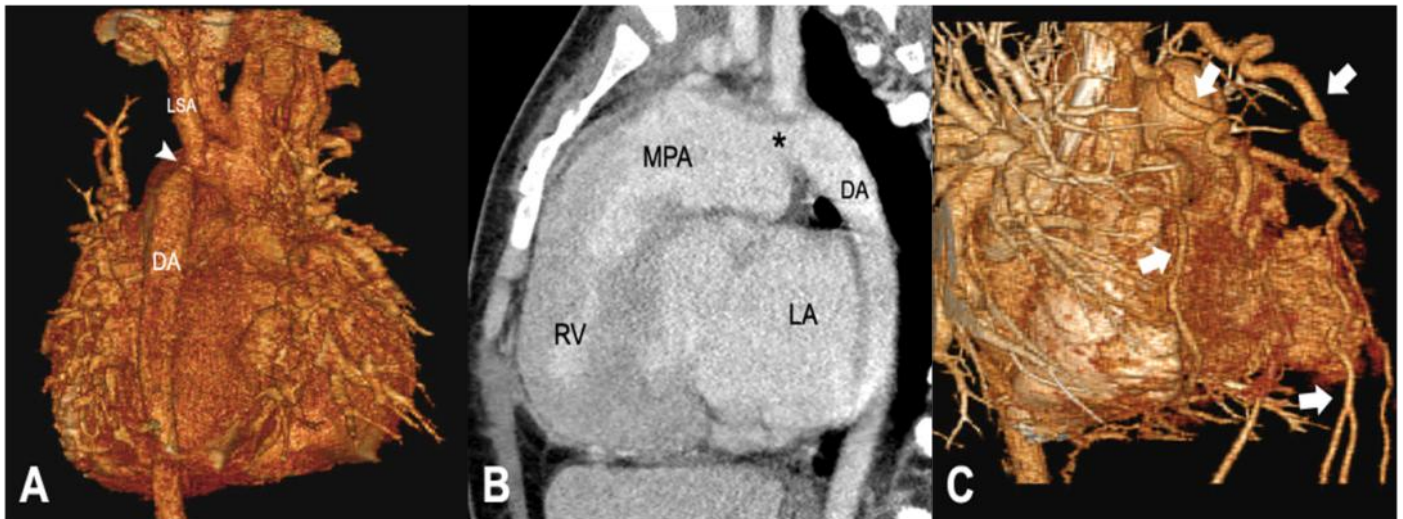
17 year old female with prior history of VSD closure. The patient was referred for CT scan because of hypertension and discrepancy between blood pressures of the upper and lower extremities. The IAA was not identified prior to this examination. Volume-rendered reconstructed image (A) shows a globularly enlarged heart with interrupted aortic arch (white arrowhead) distal to the left subclavian artery (LSA). Sagittal contrast-enhanced image (B) shows the communication (asterisk) between the main pulmonary artery (MPA) and the distal aorta (DA). There is right ventricular (RV) hypertrophy producing narrowing of the ventricular outflow tract. Another volume-rendered image (C) shows prominent intercostal arteries and collateral vessel formation (white arrows).
